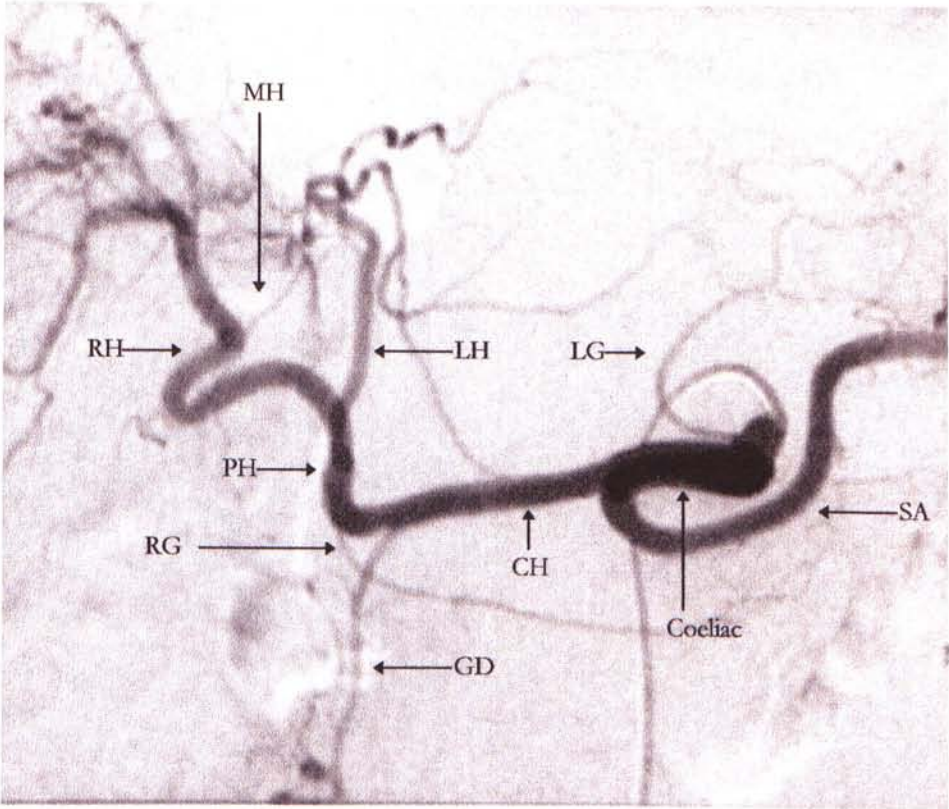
Radiograph showing classical trifurcation of the coeliac axis
